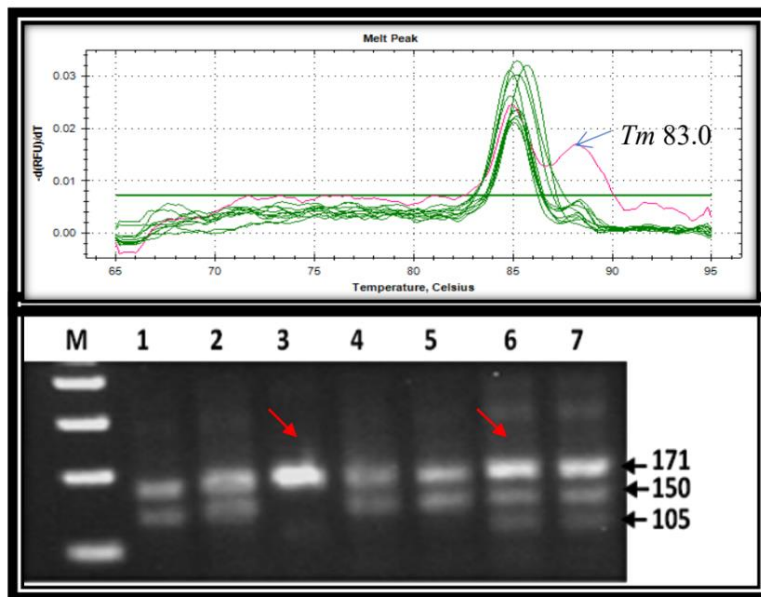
A&B): ARMS -PCR analysis of MTHFR C677T gene polymorphism showing melt peak shifting (T_m) values from 82°C (wild type CC genotype) to 83°C (Figure 3A) and, confirm the point mutation (C \rightarrow T) as shown in Figure 3A. Lane 6 and 7 (arrow) showing in heterozygous condition (CT genotype) increase “risk” factor, while rare TT genotype (lane-3) in homozygous condition showing lethality for the growing cell (Figure 3B). Lane-1,2,4 & 5 showing wild type (CC genotypes) in homozygous condition in breast cancer patients.
